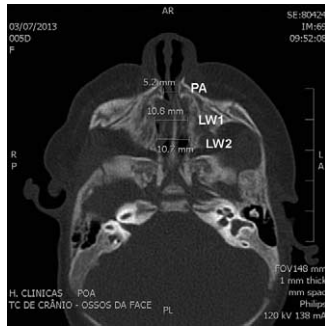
Measurement sites shown on a computed tomography scan. LW1, width of the nasal cavity at 50% of the distance between the choana and the PA; LW2, width of the nasal cavity at 75% of the distance between the choana and the PA; PA, width of the nasal cavity at the pyriform aperture.
